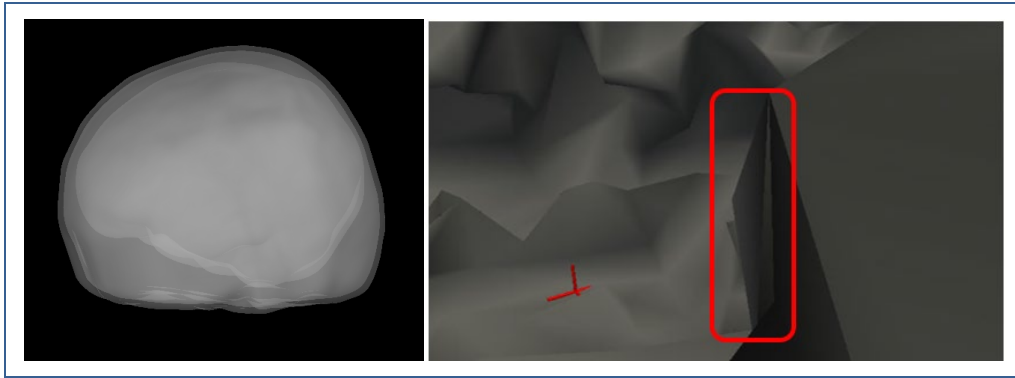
MRI\_watershed surfaces.
